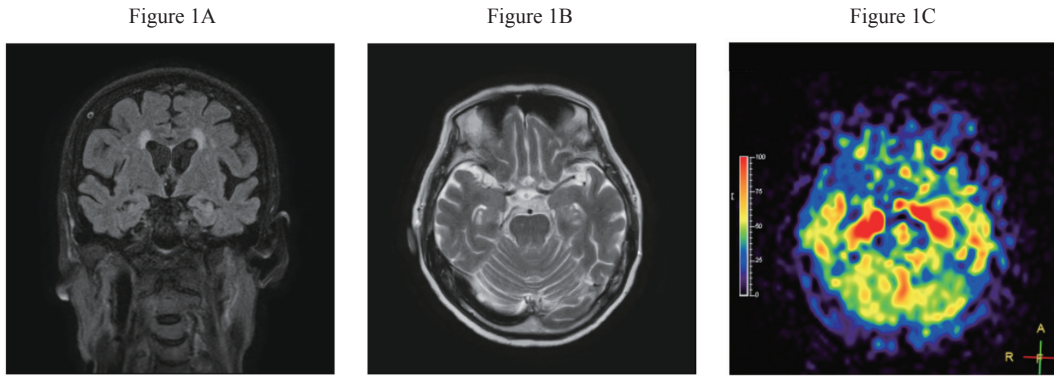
The findings of MRI and EEG on eighth day after admission.
